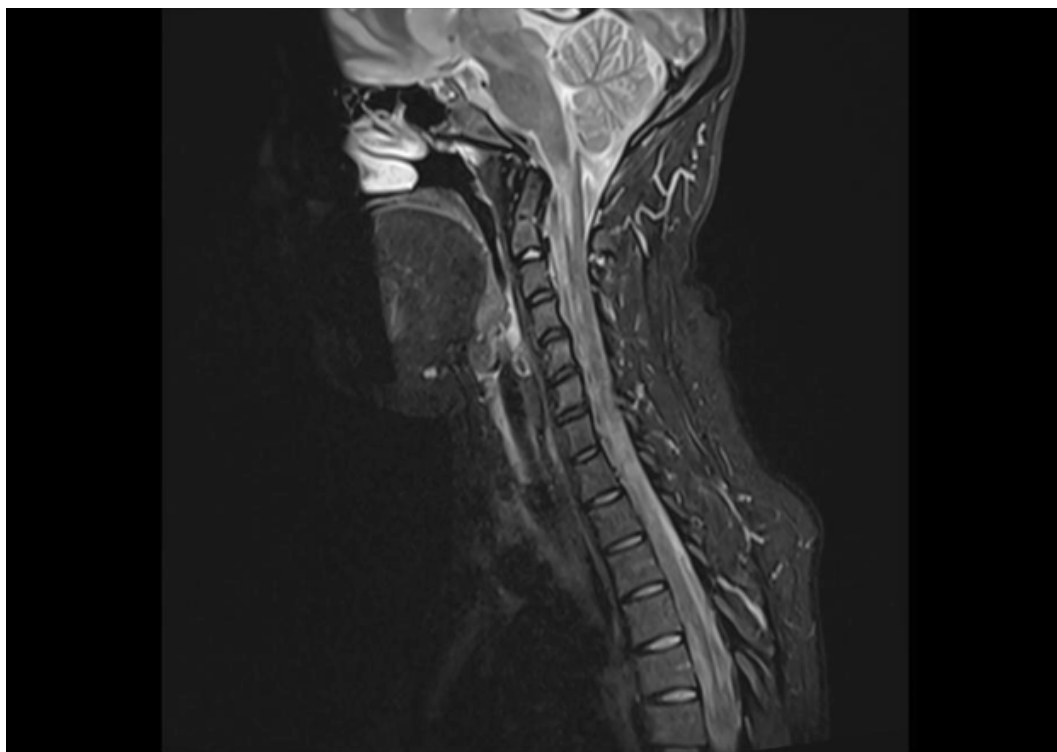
Day 3 MRI imaging displaying a large spinal cord infarction extended from cervical junction to D6.
